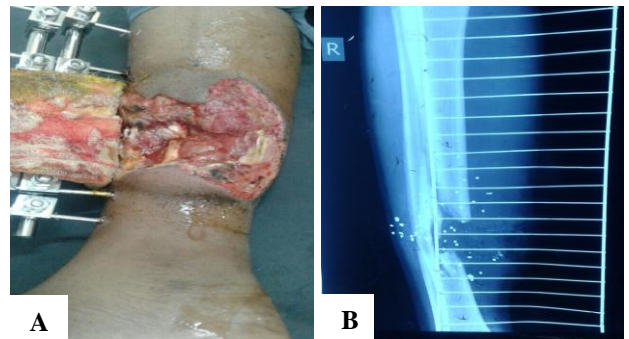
(A) Open bone leg fracture with external fixator in situ, (B) X-ray of same patient showing bone loss, (C) IRF and flap coverage of raw area done for the same patient, (D) callous formation at coticotomy site and gap closed at fracture site.
